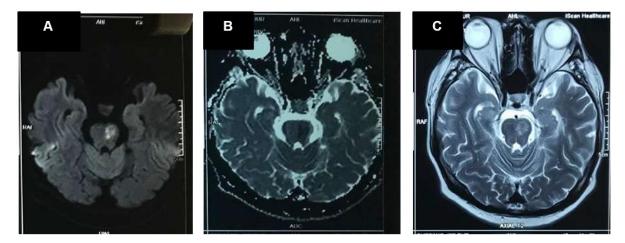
Cranial MRI at the time of evaluation showing subacute infarction in the left paramedian pons. A. diffusion weighted imaging (DWI), B. apparent diffusion coefficient (ADC), C. T2 weighted fluid attenuated inversion recovery (T2-FLAIR)
